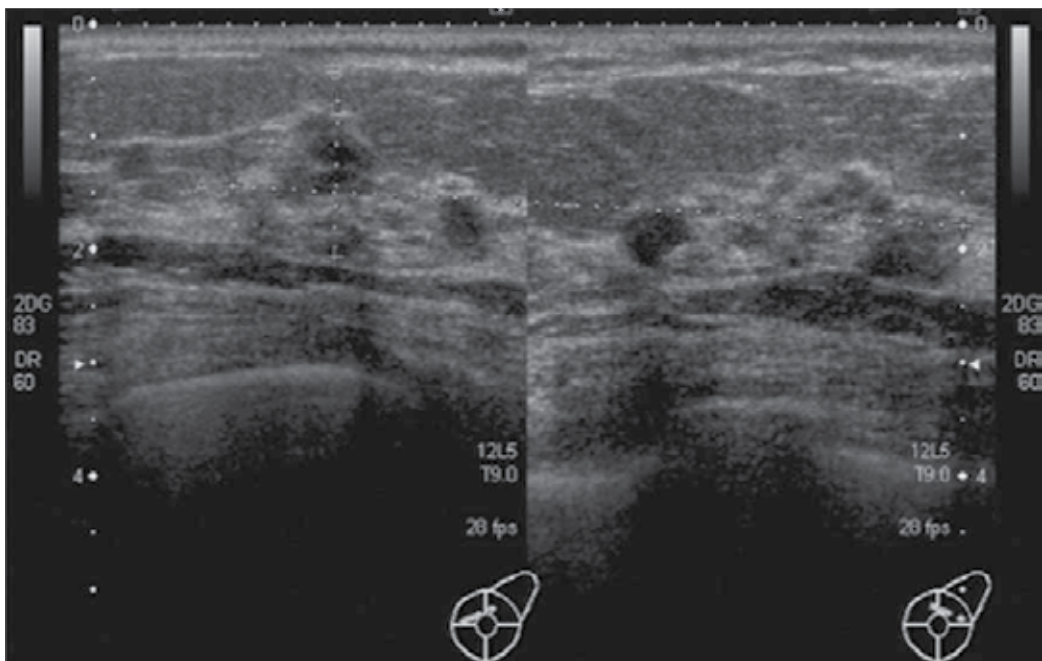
Ultrasonography of the left breast; Multiple nodular hypo-echoic masses with high Depth/Width ratio are seen and which suggested a malignant nature.
